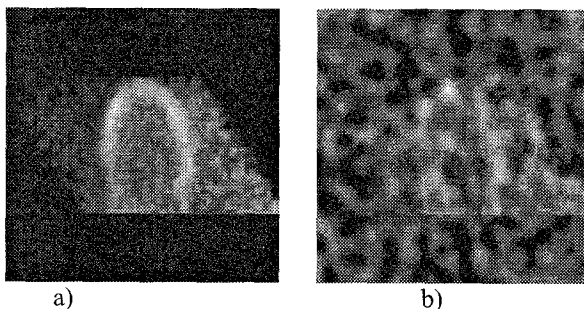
a) Original PET image, b) PET-SPECT image with SPECT noise re-scaled and added to the PET image.
